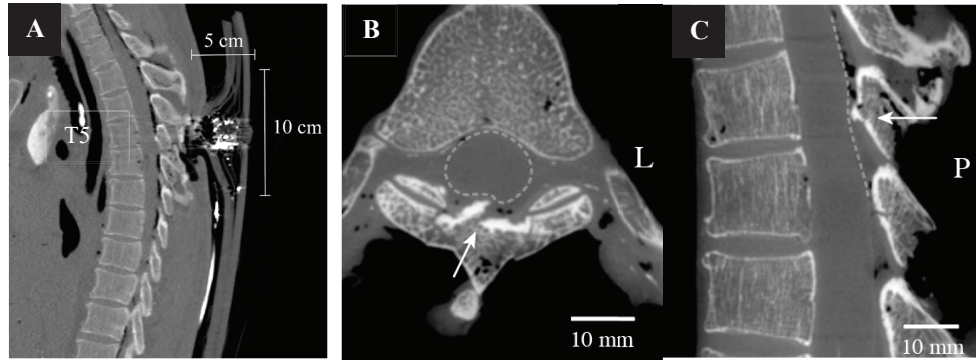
(A) Clinical CT scan showing lateral view of armour BFD spine intrusion. (B) and (C) Axial and lateral view (SPINE 06) of displaced fragments of vertebral fracture subsequent invasion into the vertebral foramen deforming the spinal cord (dotted line).
